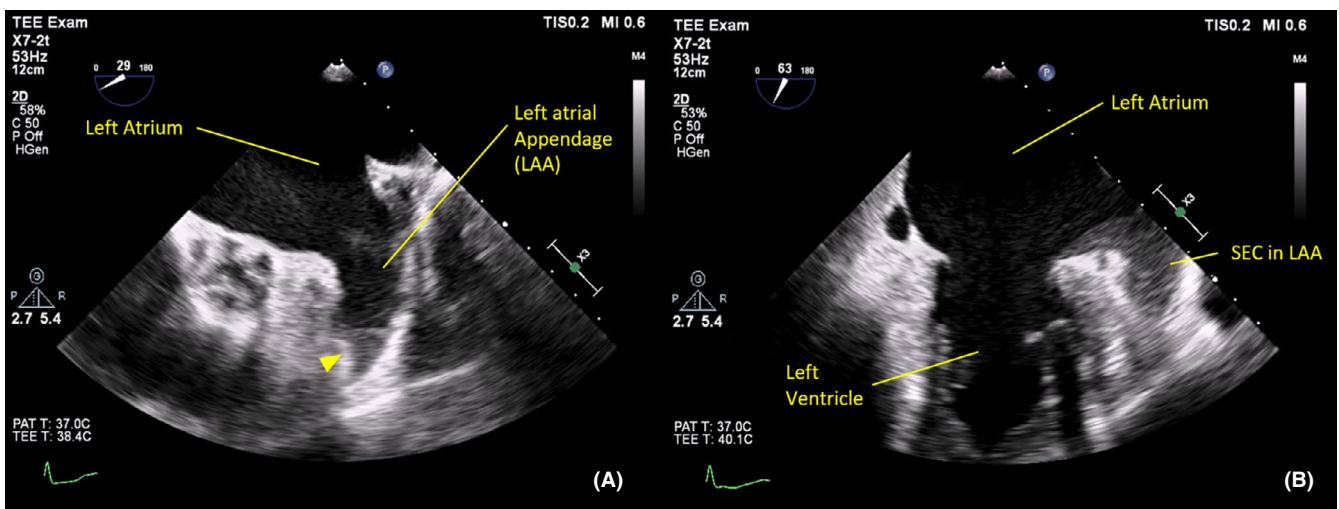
Transesophageal echocardiography after the initiation of anticoagulant therapy revealed that the thrombus and spontaneous echo contrast (SEC) were reduced. A, The thrombus was localized at the tip of the left atrial appendage (LAA) (arrowhead). B, SEC was not detected in the left atrium. SEC remained only in the LAA
